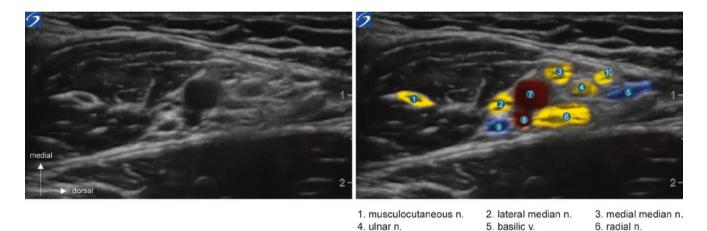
"Axillary" transverse ultrasound section showing median nerve still comprised of two components which will merge more distally
